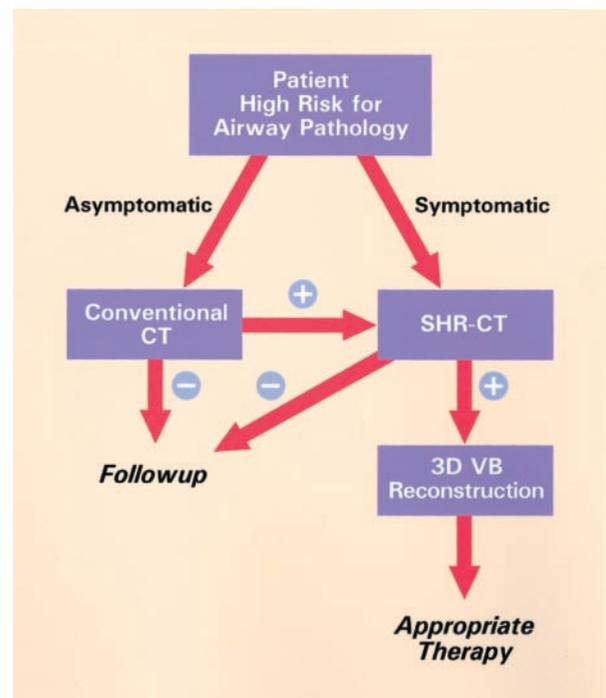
Algorithm utilizing CT scanning, SHR-CT scanning, and VB for patients who are at high risk for airway pathology.
